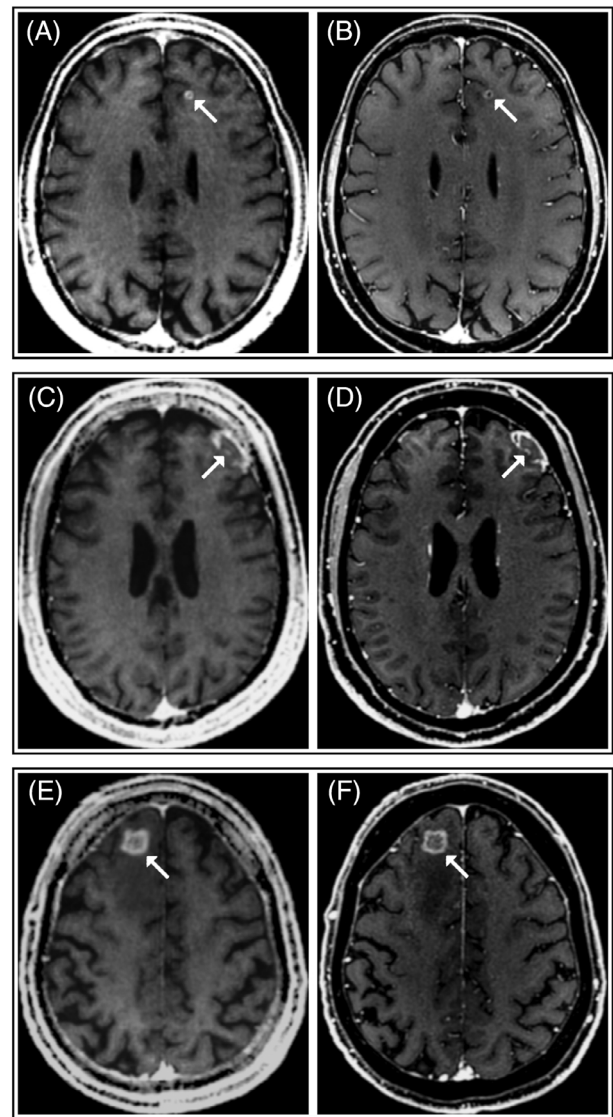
Synthetic (A, C, and E) and conventional (B, D, and F) post-contrast T1-weighted images in two patients with brain metastases and one patient with radionecrosis. Panels A and B show images of a patient with non-small cell lung cancer and an intra-axial metastasis in the left frontal lobe (arrows). Panels C and D show images of a patient with history of metastatic melanoma and a suspected leptomeningeal carcinomatosis (arrows). Panels E and F show images of a patient with melanoma and the radiological suspicion of radiation necrosis (arrows) following radiotherapy of brain metastasis. In all these patients, synthetic imaging revealed the same pattern of contrast enhancement visible in conventional imaging (ring-like in A and E, and gyriform leptomeningeal in C).
